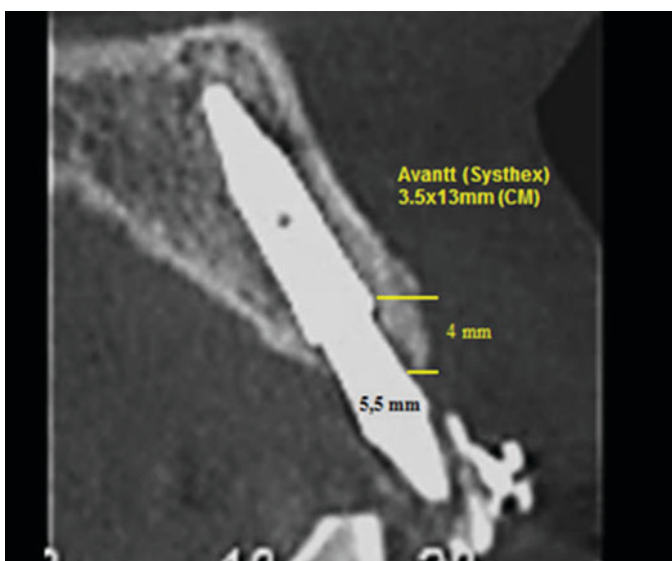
Radiographic view showing the complete reconstruction of the buccal wall.
